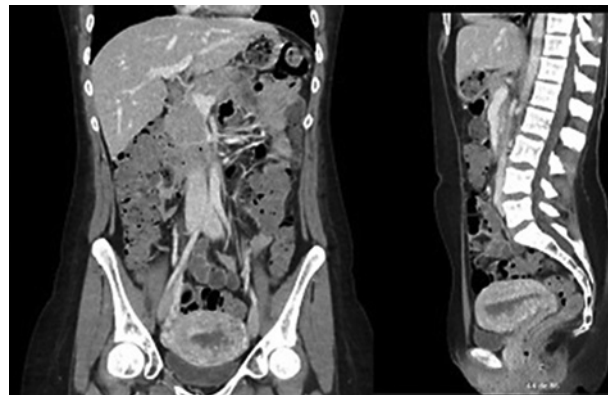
Coronal (left) and sagittal (right) view in CT scan. A hydatidiform mole in uterus with a size of 22-week pregnancy can be seen.
